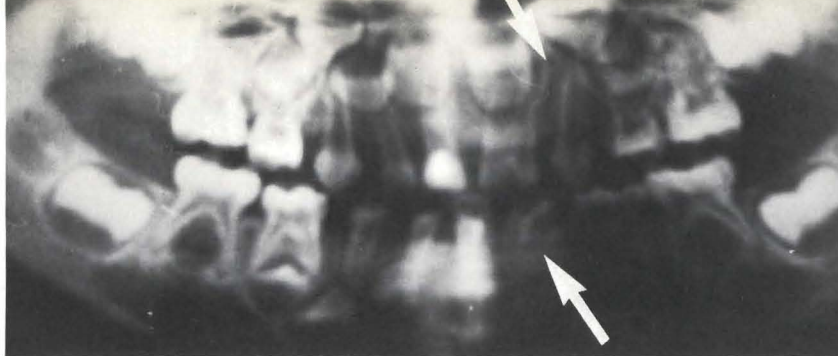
There is no radiographic evidence of the mandibular permanent lateral incisors, or of the mandibular primary right lateral incisor.
